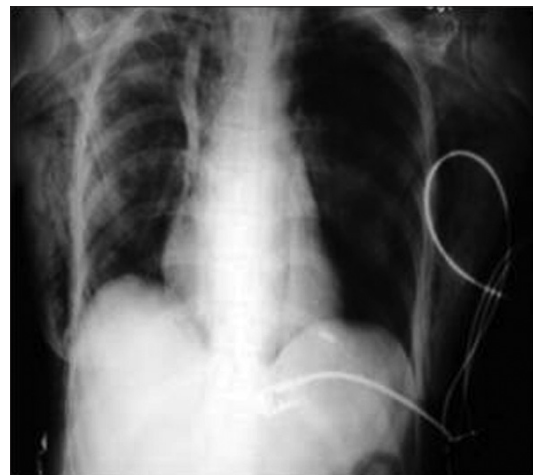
Subcutaneous emphysema on X-ray chest
